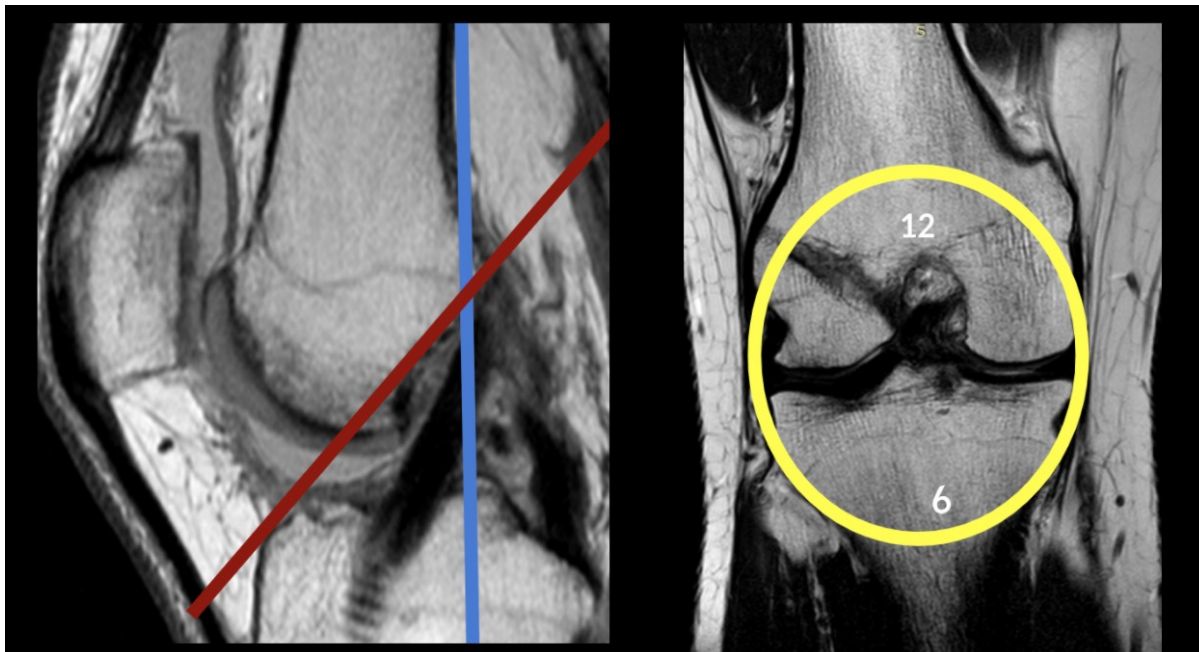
Normal position of femoral tunnel in a 28-year-old man who presented for follow-up MRI after ACL reconstruction. Sagittal and coronal T2W MR images show a normally positioned femoral tunnel. Position is between ten and eleven o'clock in this right knee.
